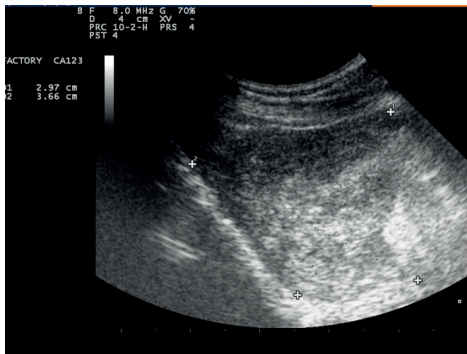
Prostate ultrasound for a patient with prostate carcinoma (FMVB)
